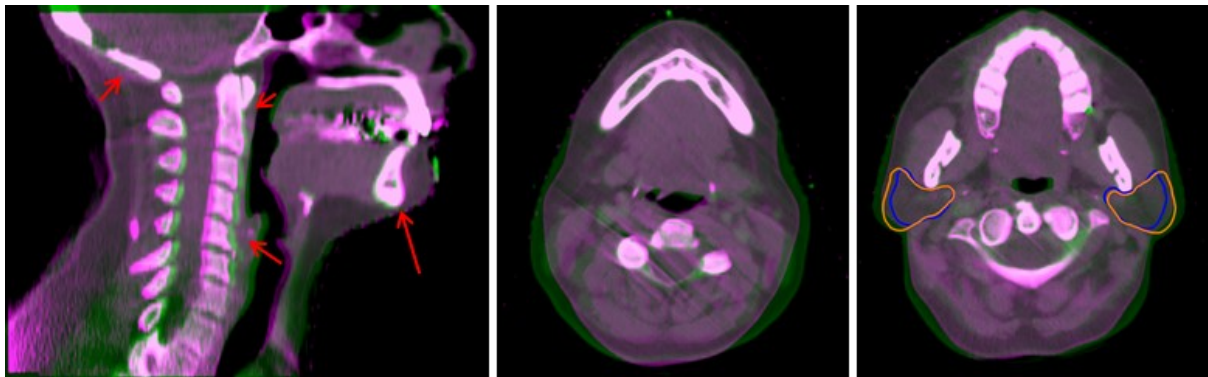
Examples of non-rigid deformations that can occur during head-and-neck radiotherapy (HNRT). The planning computed tomography (pCT) scan (green) overlaid with a during-treatment cone beam computed tomography (CBCT) scan (magenta). (Left) Non-rigid patient positioning characterised by differential movement of bony regions. (Middle) Weight loss resulting in a volume reduction of the treatment region, shown by a shrinkage of the external contour in the posterior region. (Right) Parotid gland shrinkage and shift shown by the pCT (orange) and CBCT (blue) contours.
